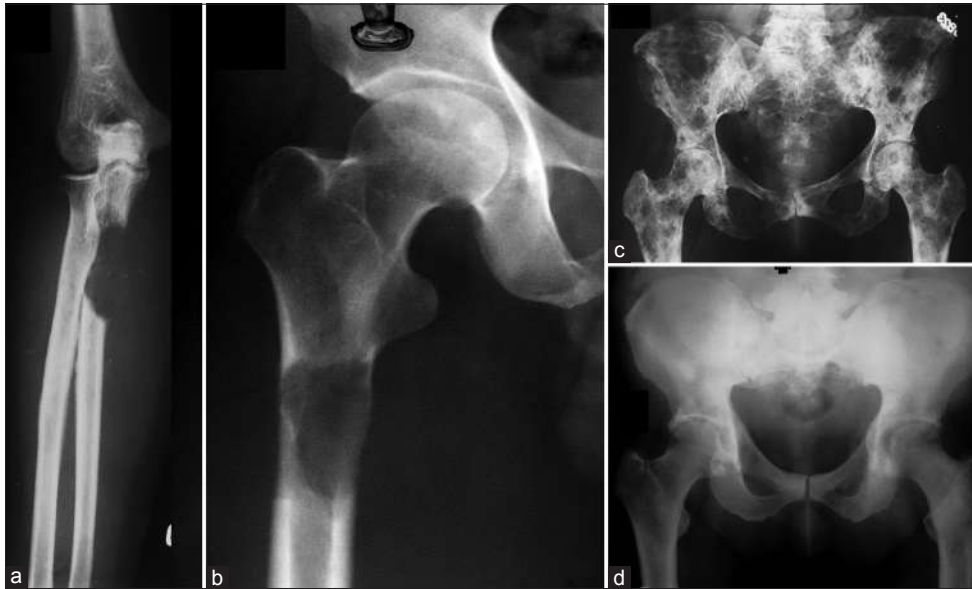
Varied radiological appearance of metastasis-lytic, mixed and blastic. (a) The radiograph of forearm with elbow joint anteroposterior view showing lytic metastasis from lung carcinoma occurring distal to the elbow (Note that metastases below the knee and elbow are rare) (b) The radiograph of hip joint with proximal thigh anteroposterior view showing an impending fracture from a lytic metastasis arising from a colonic primary. Pure lytic lesions are common with renal, lung, thyroid, uterine, adrenal, GI malignancies and melanoma (c) X-ray pelvis with both hip joints anteroposterior view showing extensive lytic and sclerotic metastases to pelvis and both femori from breast cancer. Mixed lesions are known with breast, lung, ovary, cervix, testicular malignancies and lymphoma (d) X-ray pelvis with both hip joints anteroposterior view showing pure sclerotic or blastic metastasis arising from a prostate carcinoma in a 70-year-old male. Pure blastic lesions are common with prostate, bladder cancers, medullary carcinoma thyroid and bronchial carcinoids
